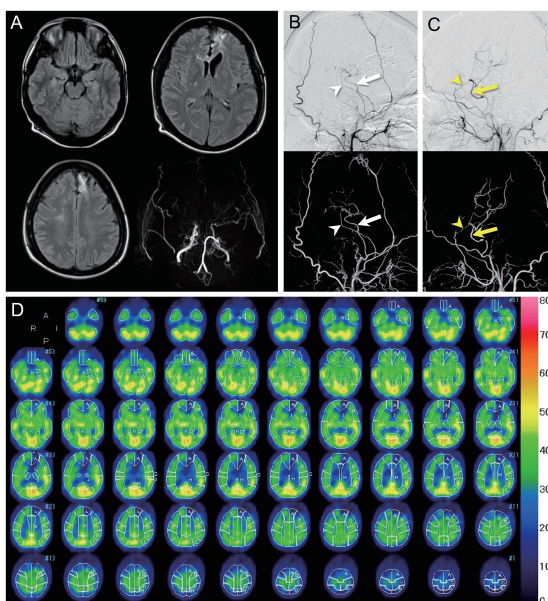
Postoperative magnetic resonance imaging (A), cerebral angiography (B), and N-isopropyl-p-[^{123}I]-iodoamphetamine single photon emission computed tomography (^{123}I -IMP SPECT) imaging two years and five months after the last stroke
